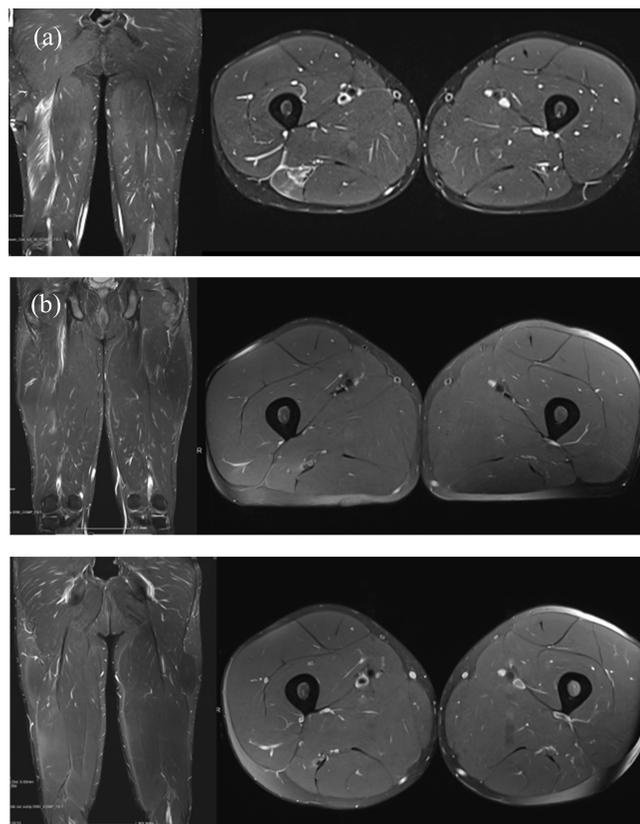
MRI findings from the posterior thigh throughout the return to sport process. MRI coronal and axial images taken on day 4 (a), day 31 (b) and day 40 (c).
